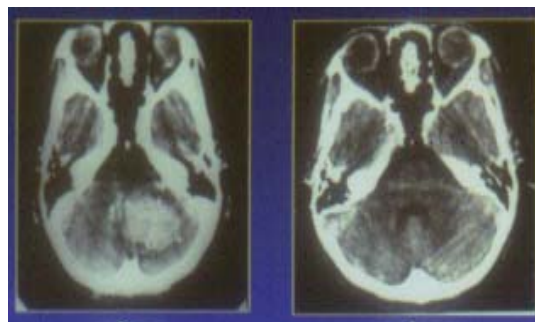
Case 5: a space-occupying lesion in right cerebellum (left, 1991) was reduced after taking ^{131}I 20.65 GBq and disappeared after 23.61 GBq (right, 1992), demonstrated by computed tomography.
